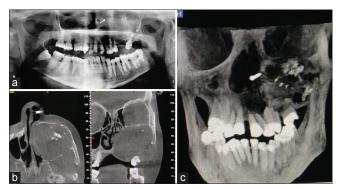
(a) Orthopantomogram showed radiopacity in the left maxillary sinus. (b) Axial and coronal cone beam computed tomography section showed soft tissue radiopacity within the maxillary sinus cavity. (c) Cone beam computed tomography threedimensional view showed irregular bony erosions with radiopaque structures on left maxillary sinus
